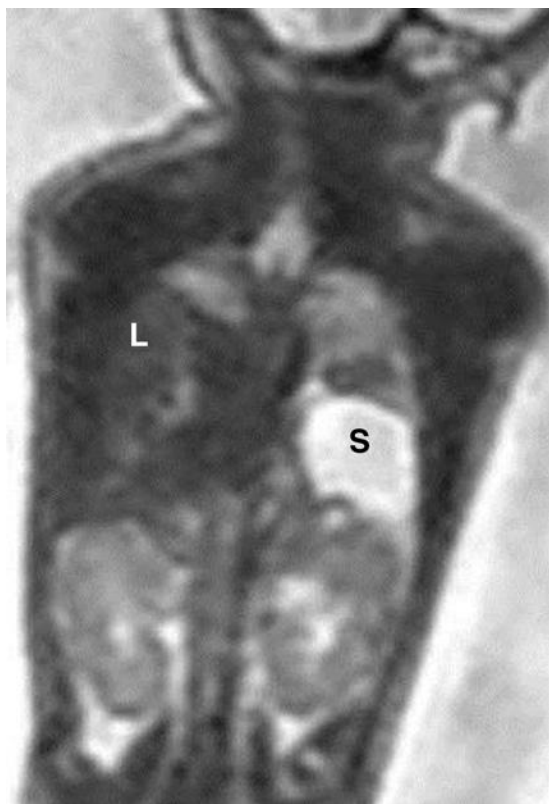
Coronal fetal magnetic resonance imaging showing bilateral congenital diaphragmatic hernia with liver (L) and stomach (S) herniated into the right and left hemithorax, respectively.
